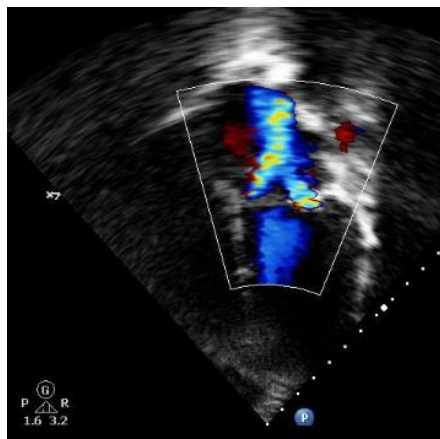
Echocardiogram 2D with color mode in apical 4 chambers shows para prosthesis mitral valvular leakage 2 jets after transplantation due to infectious endocarditis.
